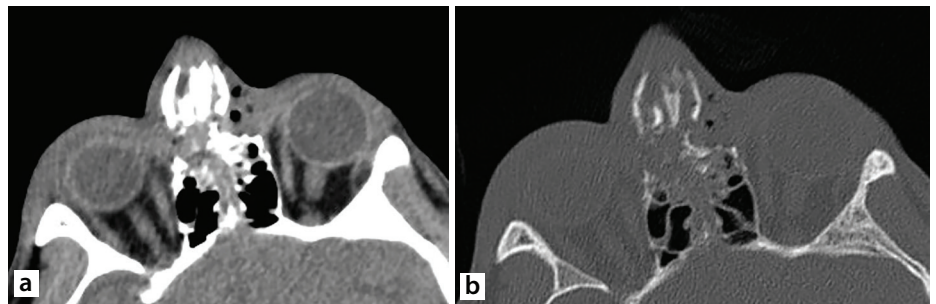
A 27-year-old Iranian man suffered blunt facial trauma due to an assault. (a, b) Computed tomography images showed perinasal and periorbital soft tissue swelling, with multiple displaced nasal bone fractures.
